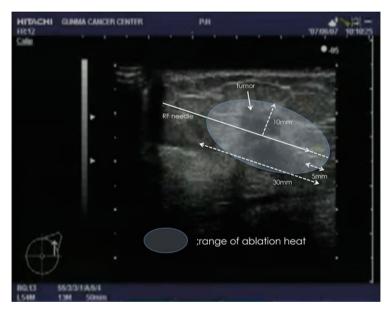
Measurement of tumor under sonographical finding
